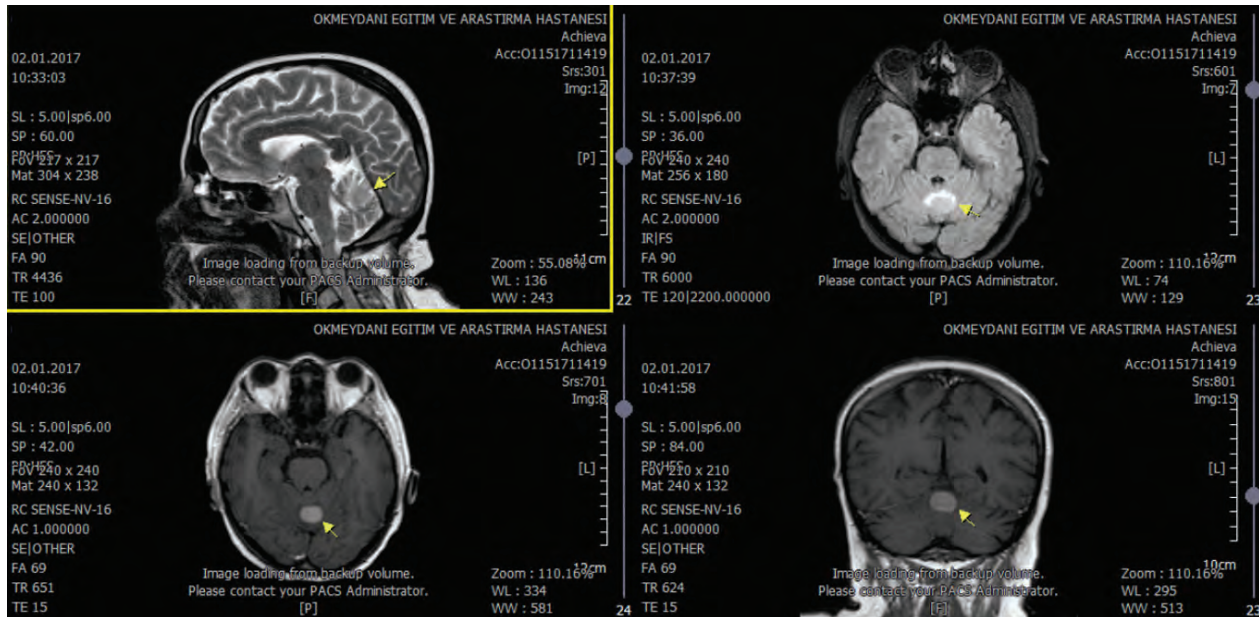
Initial MRI revealed a metastatic lesion in the vermis MRI: Magnetic resonance imaging
